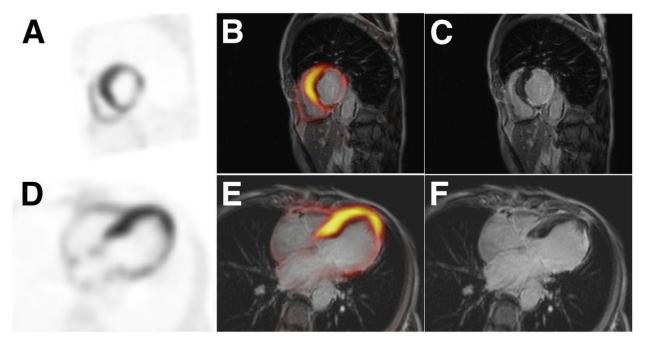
A patient with a left ventricular ejection fraction of 30% with inferior-toposterolateral akinesia on echocardiography. 18F FDG PET/MRI shows decreased metabolic activity of posterolateral wall (A and D) corresponding to late gadolinium enhancement on MR images (C and F) confirmed on fused images (B and E). Reprinted with permission (*31*).
